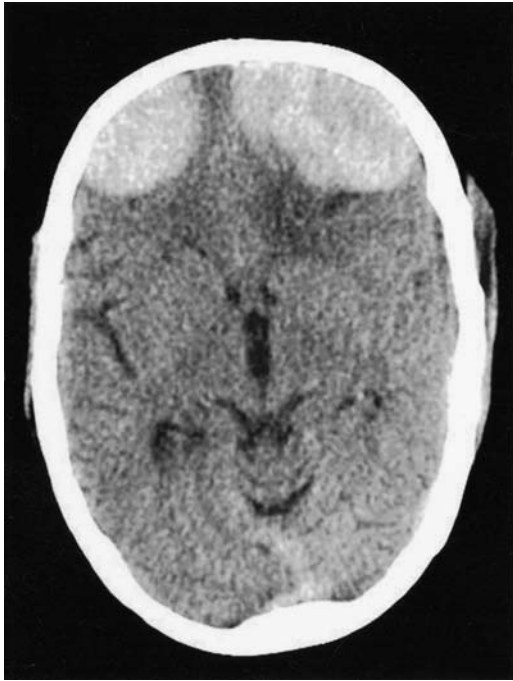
Contrast-enhanced axial CT scan of the brain revealing a well-defined, homogeneously contrast enhancing, dura-based lesion located in the bilateral frontobasal region.
